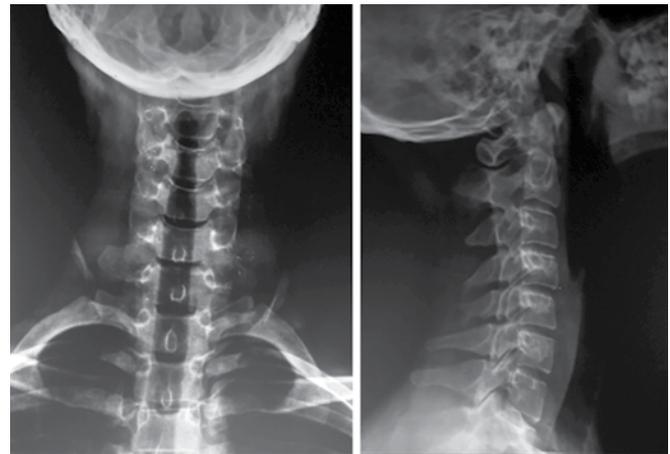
Normal radiographic evaluation of cervical spine
